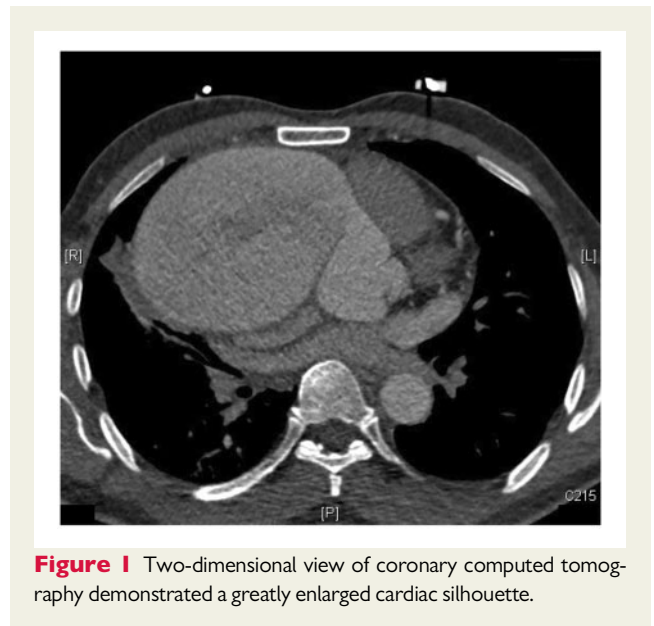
Two-dimensional view of coronary computed tomography demonstrated a greatly enlarged cardiac silhouette.
